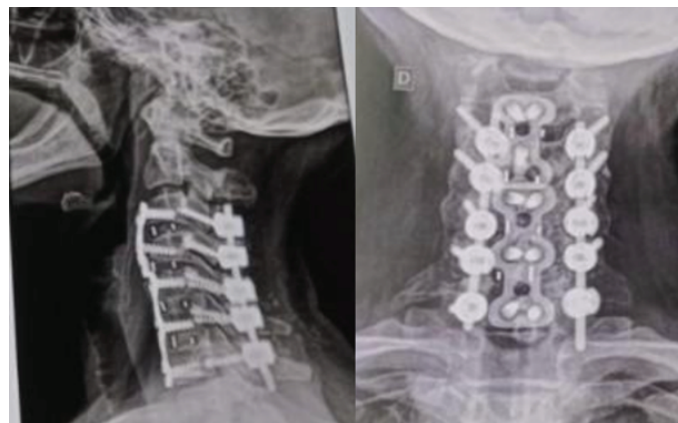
Postoperative cervical spine radiographs (lateral and AP) show anterior cages at C3–C4 and C4–C5, new cervical plate, and retained prior C5–C7 implant. Posterior fixation spans C3–C5 with lateral mass screws. Good alignment and implant placement indicate stable reconstruction.
